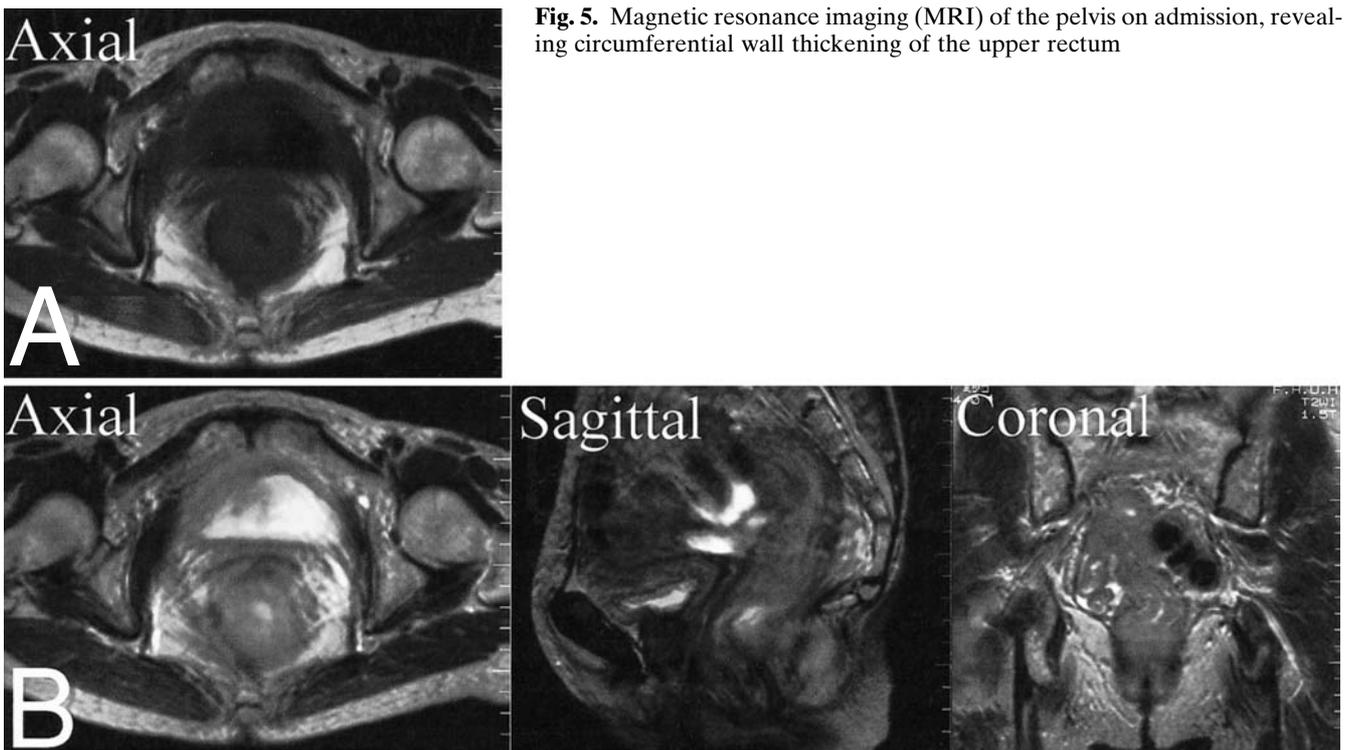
Magnetic resonance imaging (MRI) of the pelvis on admission, revealing circumferential wall thickening of the upper rectum
